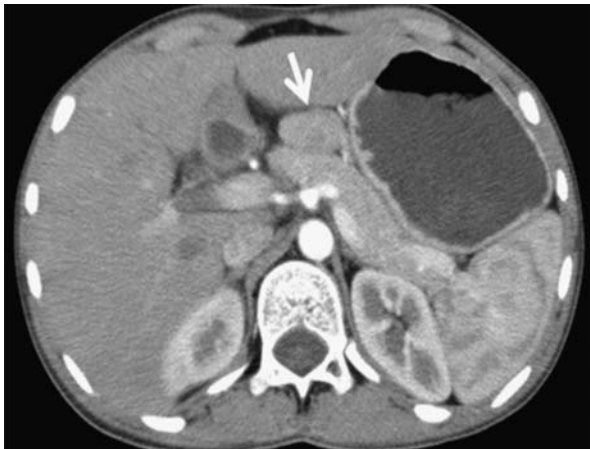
On computed tomography, a solid mass was seen between pancreas and left lobe of liver (white arrow).
